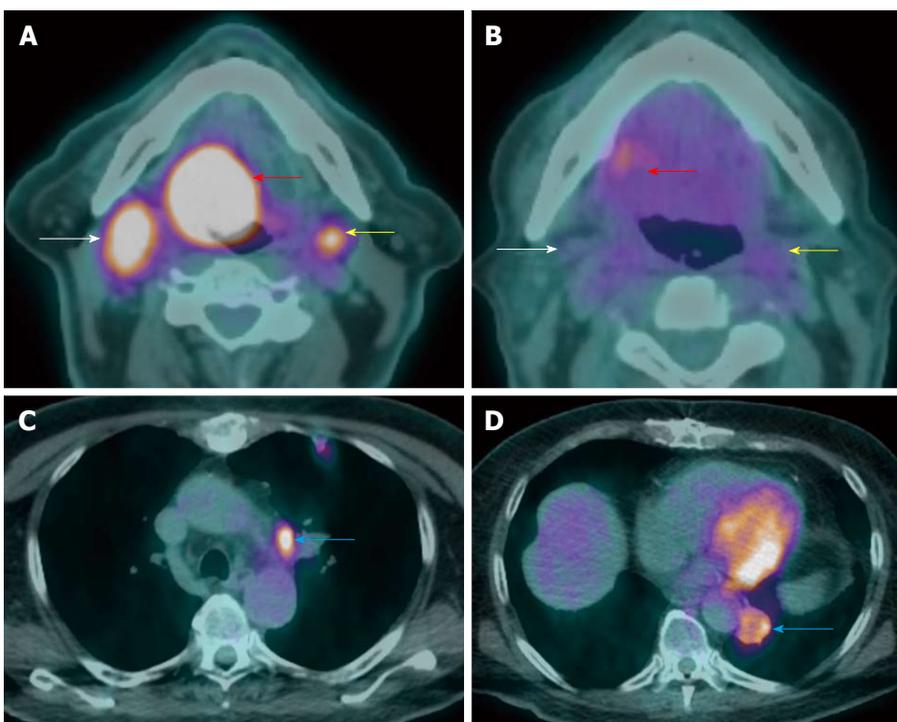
Failure of treatment due to distant metastasis. A T4aN2cM0 right base of tongue squamous cell carcinoma (red arrow) with bilateral level II a metastatic lymphadenopathy (white and yellow arrows) seen on positron emission tomography/computed tomography (PET/CT) at initial staging (A and B). The patient received chemoradiation. PET/CT (C and D) performed at 3 mo after treatment showed new lung metastases (blue arrow).
